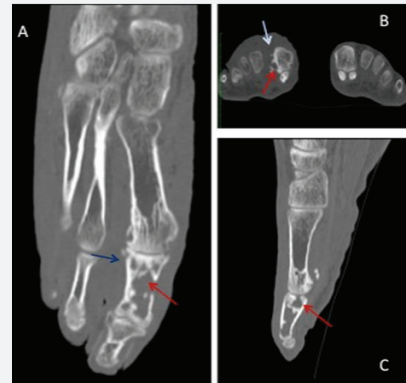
CT sections of the right forefoot: Axial reconstruction (A) in bone window of the right forefoot passing through the first ray, showing the two types of bone lesions in the mycetoma: destruction and construction. Lesions affect the 1st phalanx and the head of the 1st metatarsal. The bone lyses are regular, with dense contours and erodes the cortical that is thickened in places. Coronal (B) and sagittal (C) cut in bone window passing through the head of the 1st metatarsal, showing the regular cortical bone lyses and the thickening of the soft parts of the tarsus.
